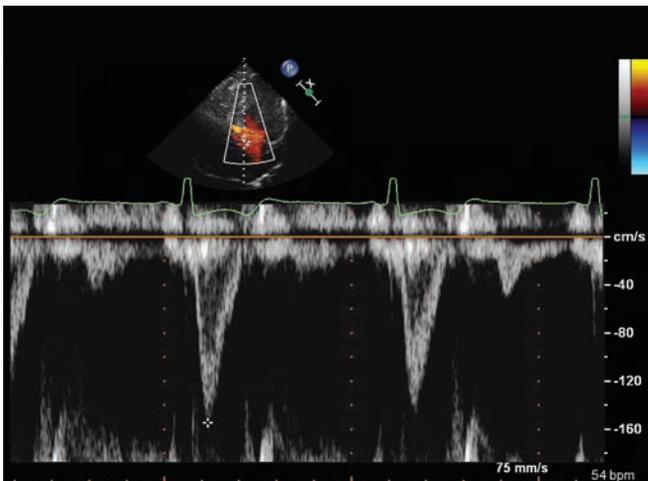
LVOT PW Doppler assessment. The pressure gradients are not significantly raised (PG 10 mm Hg).
